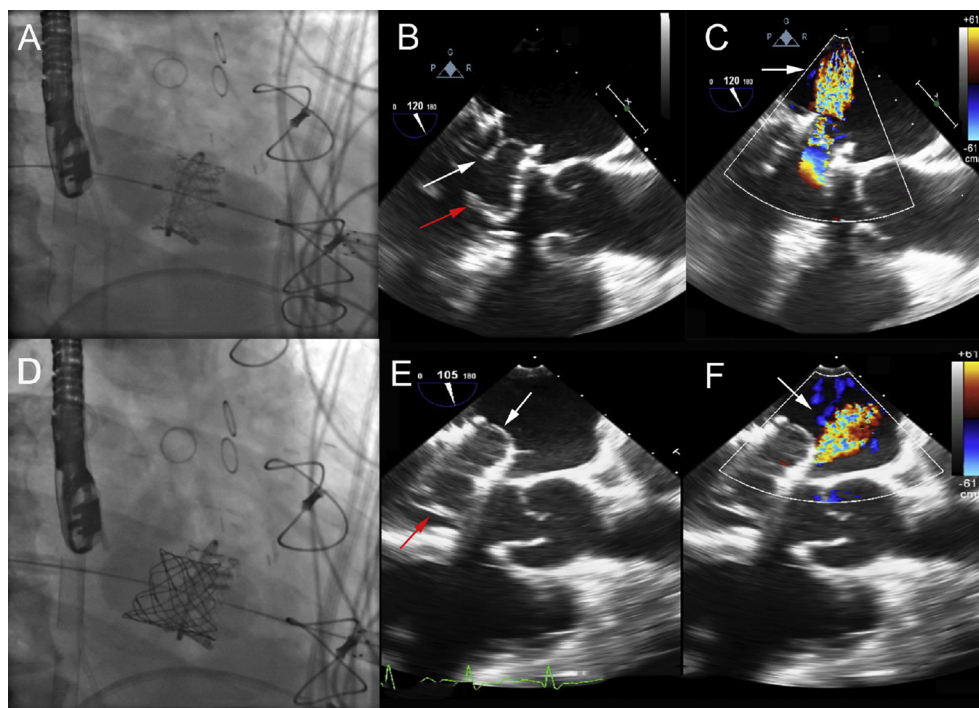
Transcatheter mitral valve-in-ring and valve-in-valve replacement. A) A 26 mm Edwards Sapien valve was deployed at the level of the mitral valve ring using a transapical approach. B) Intraoperative transesophageal echocardiogram (TEE) after mitral valve-in-ring replacement revealed native valve leaflets (white arrow) precluding closure of the prosthetic leaflets (red arrow) with resulting C) severe central MR by color Doppler (arrow). D) A 22 mm Melody valve was deployed further into the atrium away from the prolapsing leaflet. E) TEE after mitral valve-in-valve replacement revealed functioning transcatheter valve leaflets (red arrow) with non-interfering native valve leaflets (white arrow) F) Color Doppler showed resolution of central mitral regurgitation but residual paravalvular leak (arrow).
